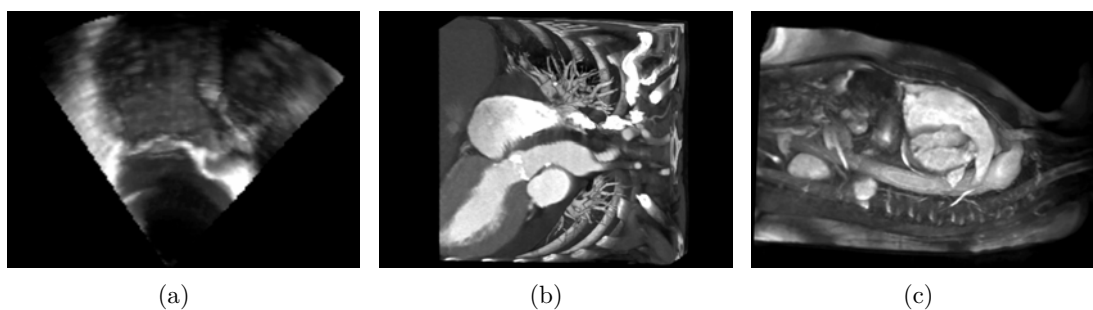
Examples of cardiac data: (a) TEE study, (b) cardiac CT study. and (c) CMR study.
